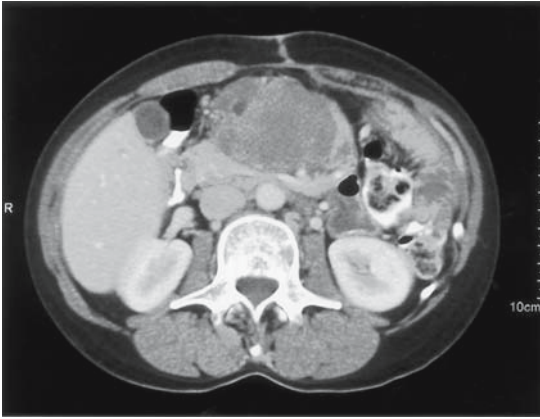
Abdominal CT scan: desmoid tumor is root of mesentery engulfing superior mesenteric artery/vein.
